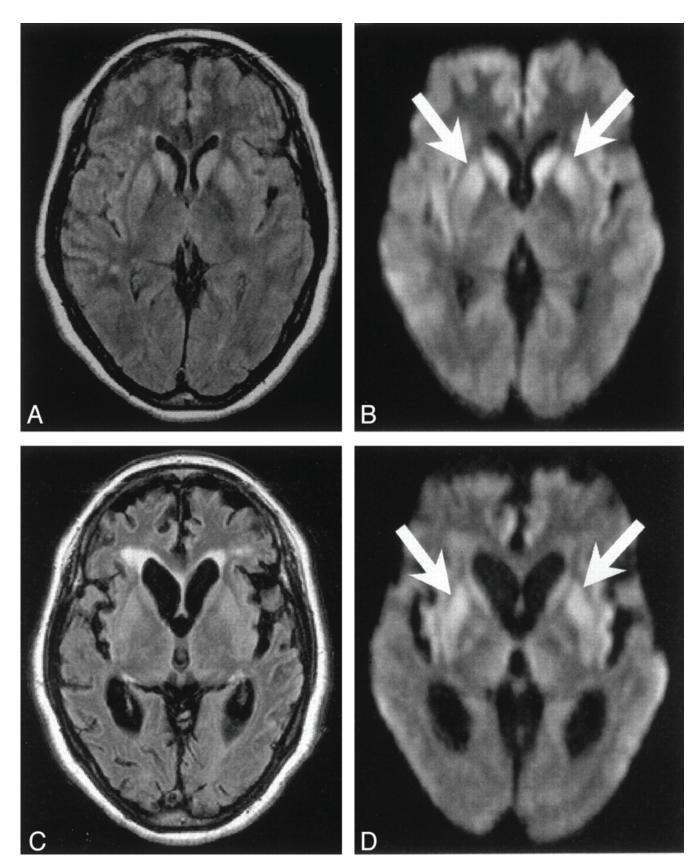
MRI of brain revealed symmetrical high signal intensity in caudate nucleus and putamen on DWI and T2WI
